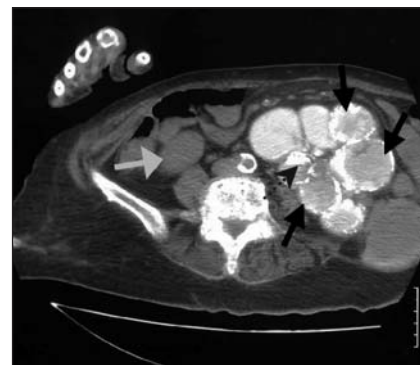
Computed tomography scan of the abdomen showing renal stone (dashed arrow) and cystic lesions (black arrows). Low pole of the normal right kidney is indicated with the grey arrow.
